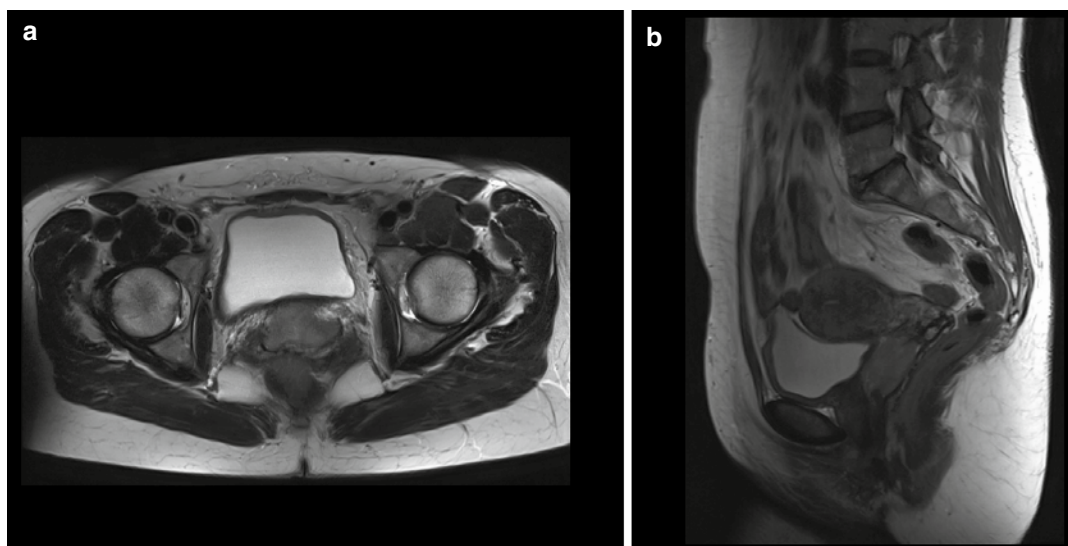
oT3a vaginal carcinoma infiltrating the anterior mesocolpos. T2-weighted transverse (a) and sagittal (b) MRI scans show a vaginal tumor extending into the vesicovaginal septum
